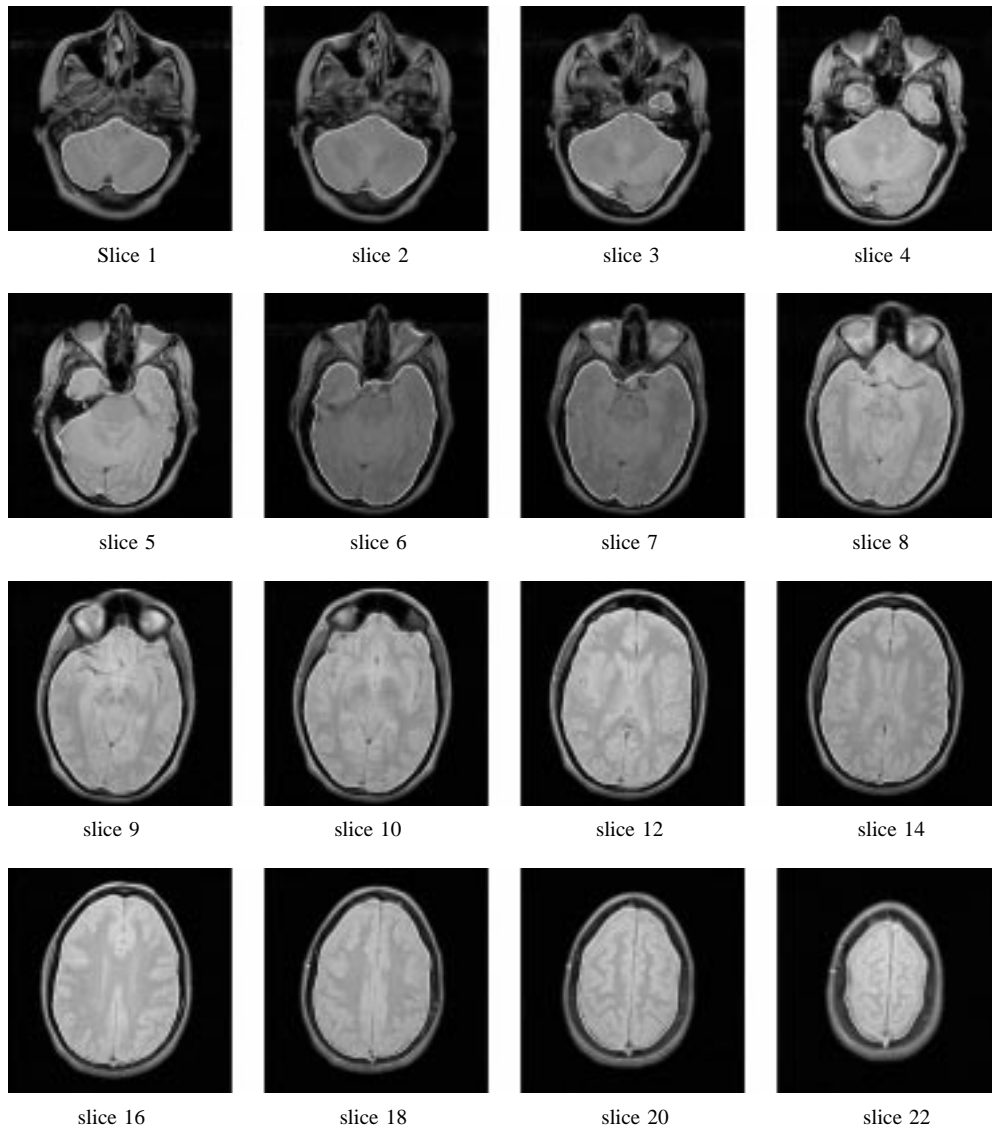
An automatically detected intracranial contour overlaid on selected slices of a PD-weighted MRI scan.
